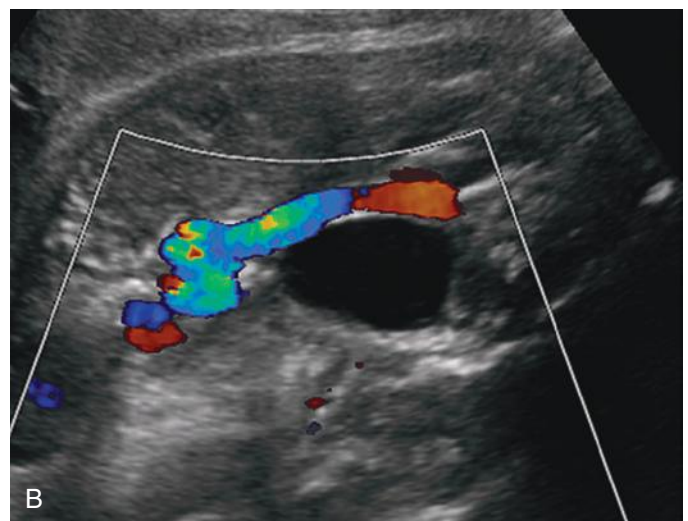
Single umbilical artery, also called two-vessel cord. A, In cross section, only one umbilical artery and vein are visible. Because two umbilical arteries may sometimes fuse near the placental cord insertion, suspected single umbilical artery should be confirmed at the level of the fetal bladder. B, Color Doppler imaging shows only one umbilical artery adjacent to the fluid-filled bladder.
